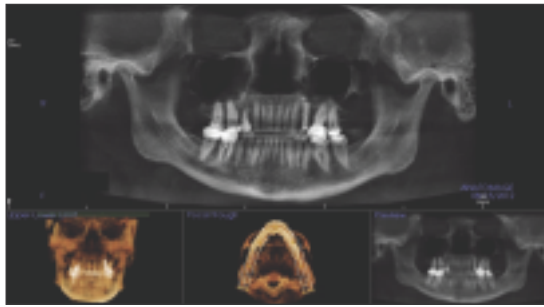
CBCT scan provided 3-D information on the condyles.
